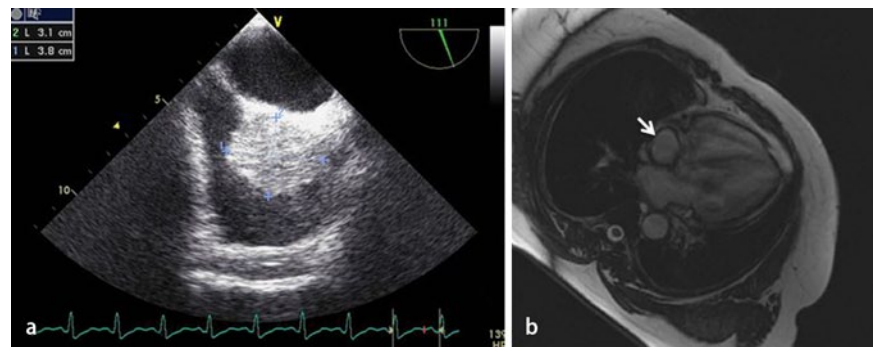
▲ a Transesophageal echocardiography of the mass. b Magnetic resonance imaging; arrow shows the encapsulated mass
